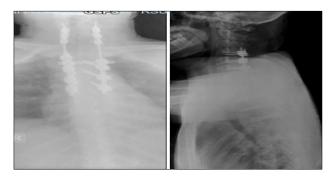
Plain X-ray taken on the first month followup showing stable construction.
